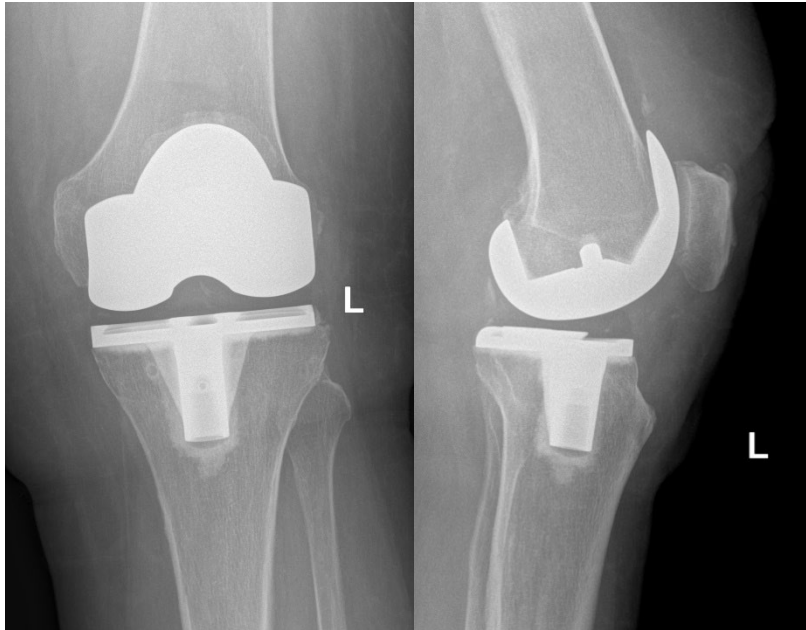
Postoperative Anteroposterior and Lateral X-ray views of the knee.
